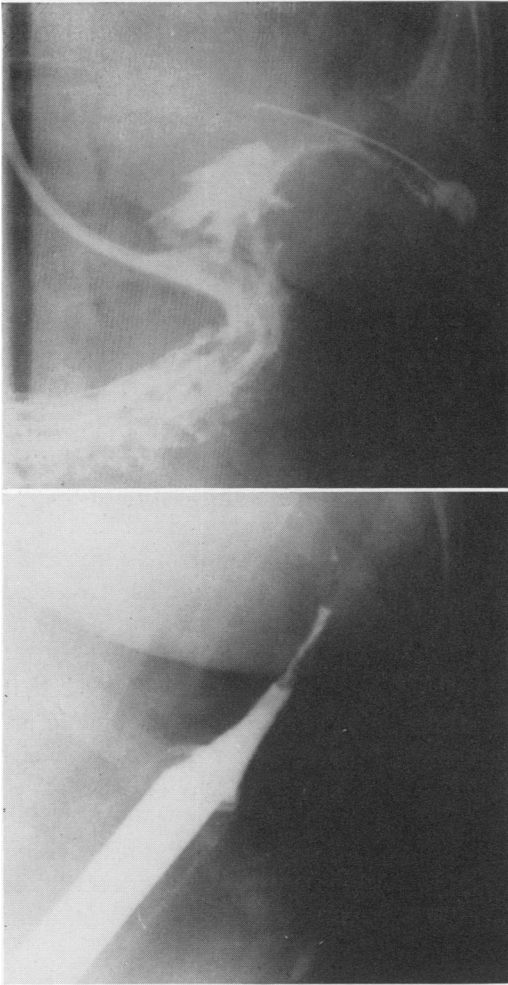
(top). Case 1. X-ray of gastrograffin meal showing persistence of fistulous tract 6½ weeks postoperative.
